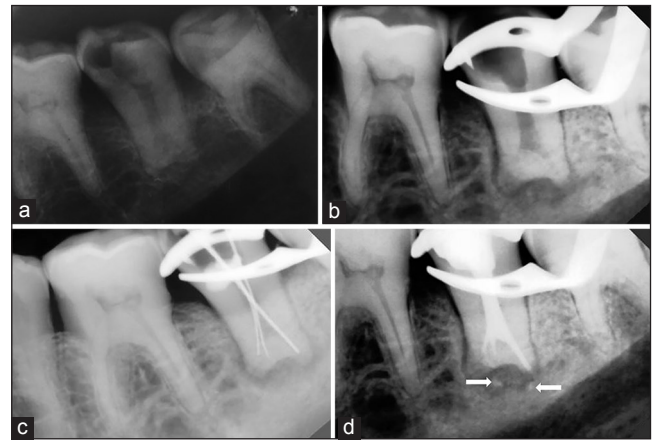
(A) Intraoral peri-apical radiograph showing deep coronal caries, (B) Preoperative radiograph after caries excavation, (C) Working length determination, (D) Final image after root canal obturation and white arrows indicates extrusion of gutta-flow
